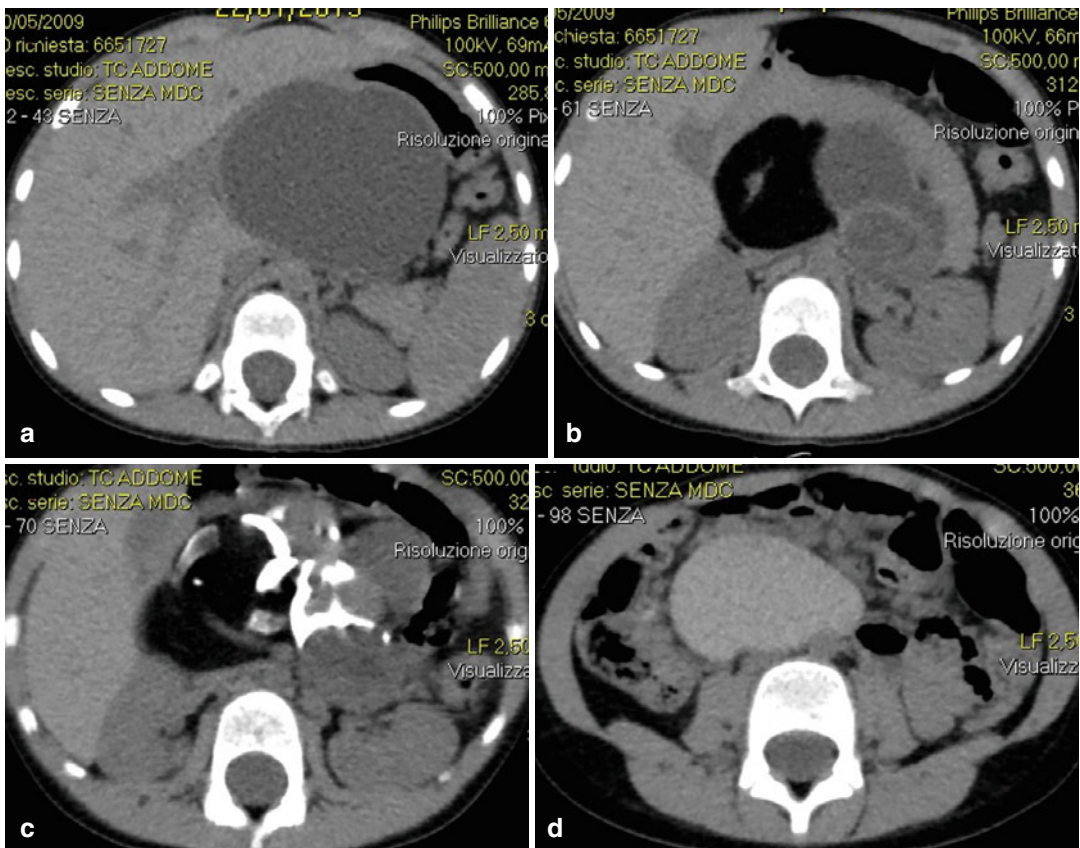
A CT was then performed. In these unenhanced axial scans, a large retroperitoneal mass with cystic, fat, bone and sebaceous components is depicted. A retroperitoneal mature cystic teratoma was diagnosed
